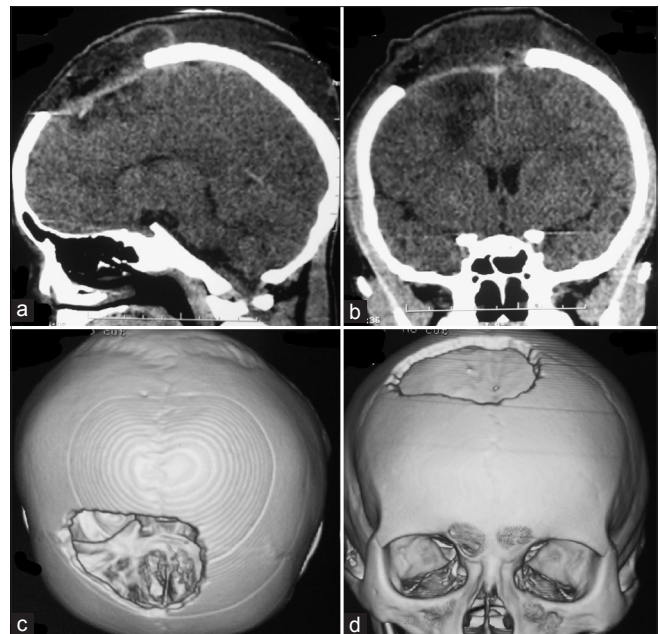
Postoperative CT brain (a) sagittal (b) coronal views and (c and d) 3D reconstructed view
